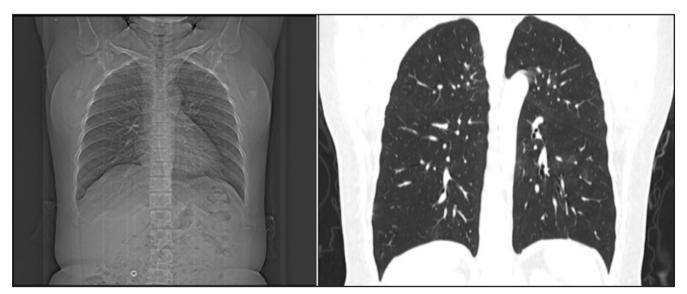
Chest HRCT with a peripheral ground-glass pattern in all four quadrants, predominantly the upper left.
